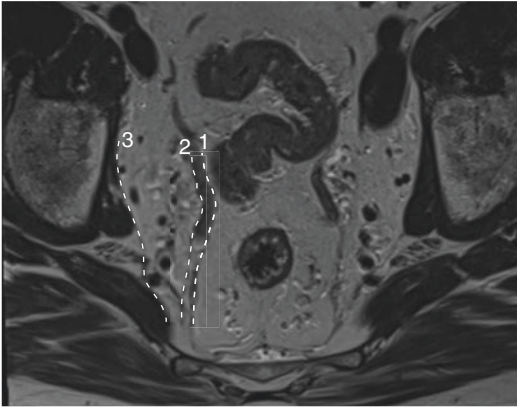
MRI demonstrating planes of the right pelvic sidewall: mesorectal plane (1), ureteric plane (2), and bony plane lateral to internal iliac vessels (3)
